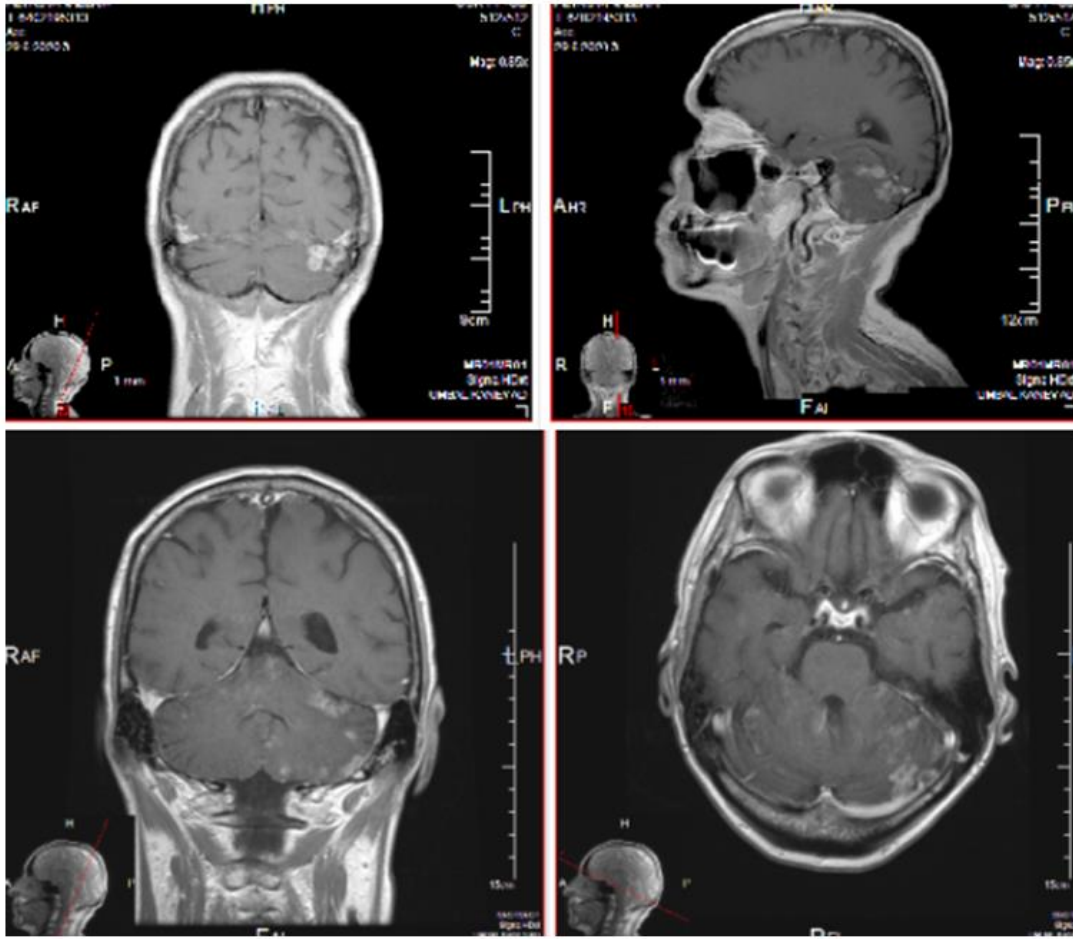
COR T1 FLAIR+C, SAG T1 FLAIR+C, AX T1 FLAIR+C MR postcontrast images after 2 months of RT
